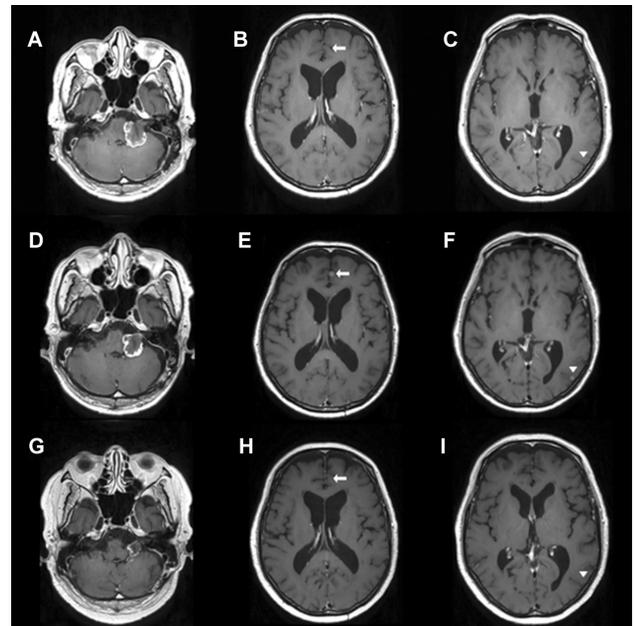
Changes in MRI images before and after therapy. (A) Initial T1-weighted MR image with gadolinium contrast showing an enhancing mass in the left CPA and no other enhancing lesions (B, C) before adjuvant cyberknife radiotherapy. (D) T1-weighted MR image with gadolinium contrast 3 weeks after cyberknife radiotherapy showed that the mass in left CP angle was reduced. (E, F) However, the metastatic lesions in the frontal (arrow) and parietal lobes (arrowhead) had grown. A third T1-weighted MR image with gadolinium contrast after four chemotherapy cycles showed that the mass in left CPA had reduced (G) and metastatic lesions in the frontal and parietal lobes disappeared (H, I).
